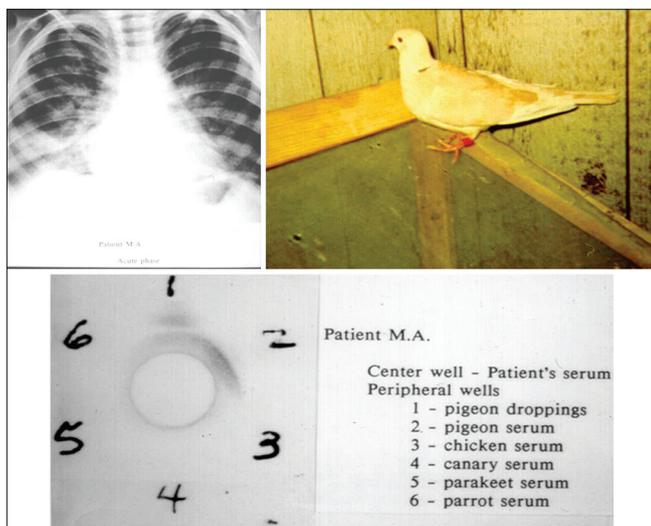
(upper left) Initial chest x-ray; (upper right) One of the pink doves, a type of pigeon, that were raised in the front room of their house; (lower) Ouchterlony double-gel diffusion plate with precipitin lines for pigeon droppings and pigeon serum.
